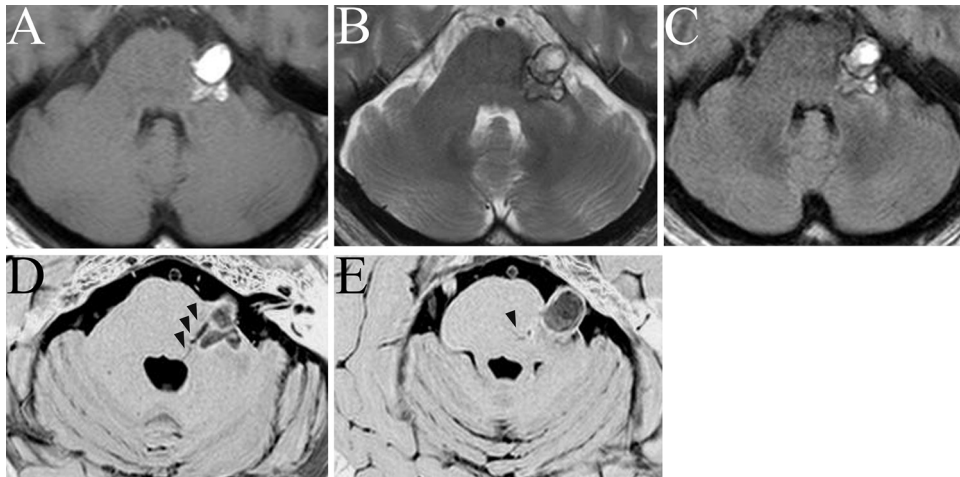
MRI findings showing a left cerebellopontine angle mass 3 cm in diameter in contact with the trigeminal nerve. Highintense axial T1-weighted images (A) and isointense to highintense T2-weighted (B) and FLAIR-weighted (C) MRIs show a left trigeminal mass with hemosiderin rims. Axial CISS-weighted findings (D, E) show a low-intense mass with a hemosiderin rim and DVA (arrowheads).
